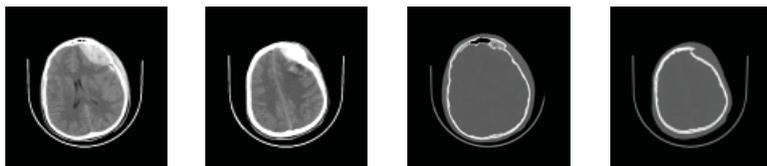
The initial CT brain obtained in the ED. (a) Large acute EDH with contusion just posterior to the hematoma. (b) The area of the depressed fracture showing the underlying brain contusion. (c) Bone window demonstrating the fracture line that is going through the pterion. (d) Bone window demonstrating the extent of the depressed fracture in the left frontal region
